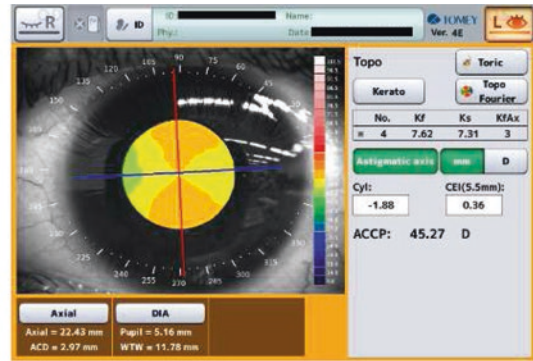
Ultrasound biometer AL-4000
